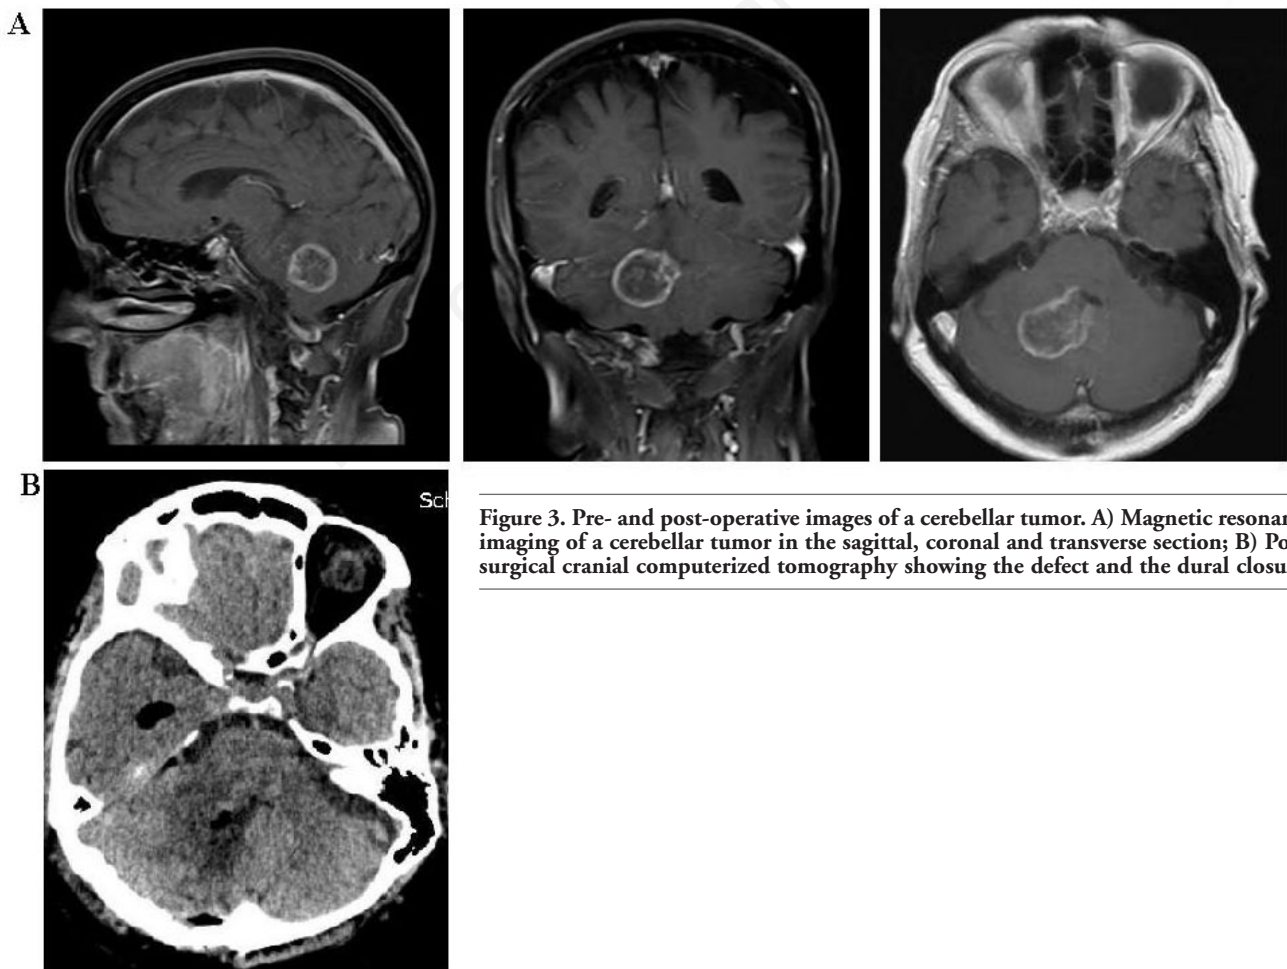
Pre- and post-operative images of a cerebellar tumor. A) Magnetic resonance imaging of a cerebellar tumor in the sagittal, coronal and transverse section; B) Post-surgical cranial computerized tomography showing the defect and the dural closure.
